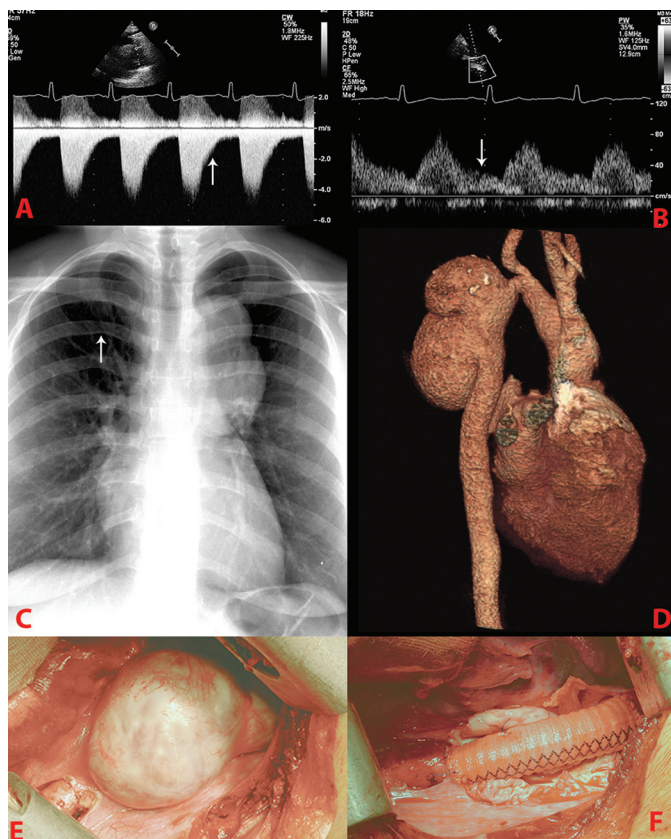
(A) Echocardiography: suprasternal view with continued Doppler waves of the descending aorta with diastolic runoff, as indicated by the arrow. (B) Echocardiography: pulsed wave Doppler of the abdominal aorta with diastolic runoff as indicated by the arrow. (C) Chest radiography showing rib notching (indicated by arrow) and aortic aneurysm. (D) See Video 1: 3D reconstruction of CT angiogram showing an aortic aneurysm of 4.5×8.8 cm. (E) Photograph of the aneurysm during operation. (F) Photograph of graft interposition after operation.
